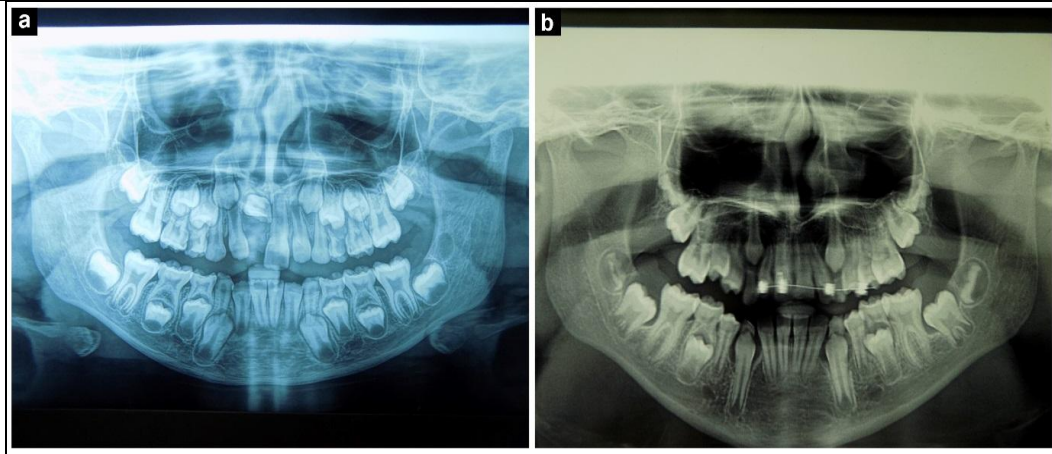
Orthopantomographic image of a girl with the impacted central maxillary incisor on the right side (a-before and b-after therapy)
